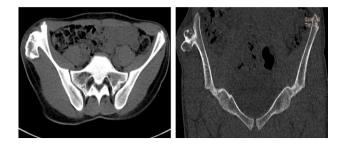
CT scan of the pelvis: a well-defined, expansile, pedunculated, polypoidal lesion arising from the lateral aspect of the right iliac wing.
